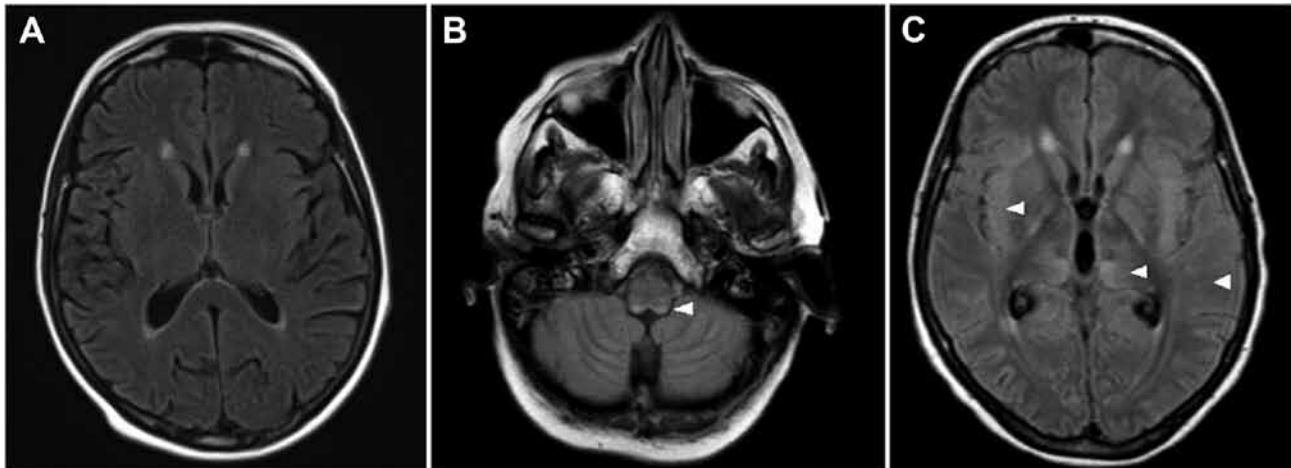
Magnetic resonance imaging axial flair sequence of brain of 66-year-old woman with fatal encephalitis, Bordeaux, France, 2012. A) No hypersignal at day 6. B) Bilateral posterior hypersignals in the medulla at day 13. C) Bilateral supratentorial hypersignals at day 24 in the cortex, the white matter, and the basal ganglia. Hypersignals are indicated by white arrowheads.
